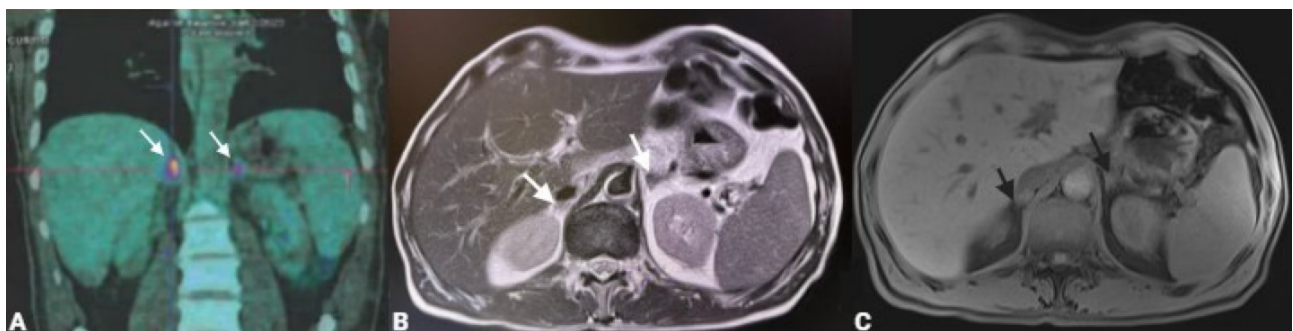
Adrenal involvement radiological evolution. A: FDG PET-CT at diagnosis moment, showing intense uptake in both adrenal glands (white arrows); B: abdominal MRI (T2-sequence) 3 months after the diagnosis, showing atrophy of both adrenal glands (white arrows); C: abdominal MRI (Dixon method) 6 months after the diagnosis, showing almost complete disappearance of both adrenal glands (they supposed to be placed where black arrows are pointing out), comparing to the previous MRI. FDG PET-CT, fluorodeoxyglucose positron emission tomography-computed tomography; MRI, Magnetic resonance imaging.
